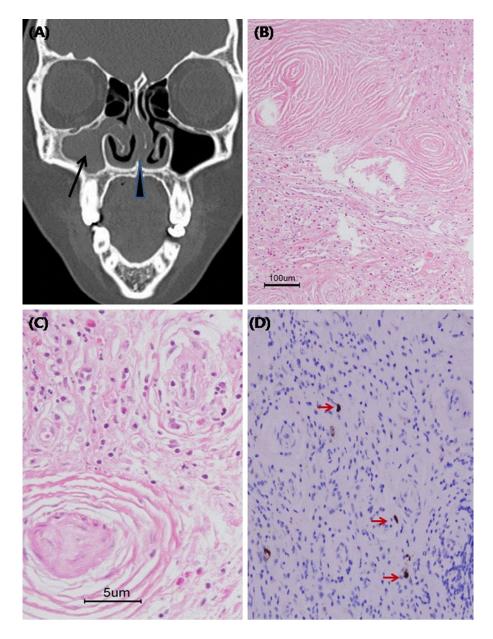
Ostiomeatal unit (OMU) computed tomography (CT) and biopsy of a mucosal lesion in the right maxillary sinus
